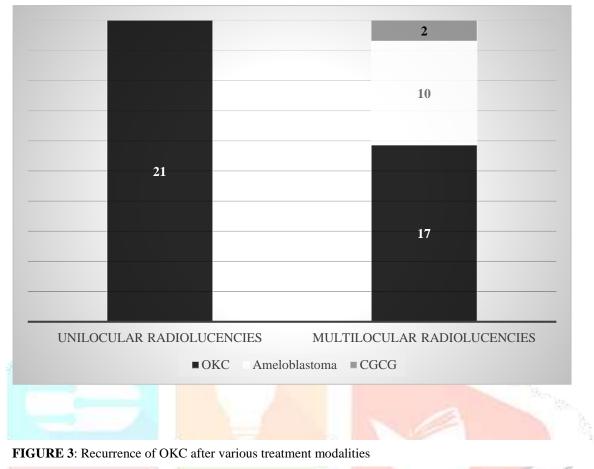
Radiographic presentation of osteolytic lesions
